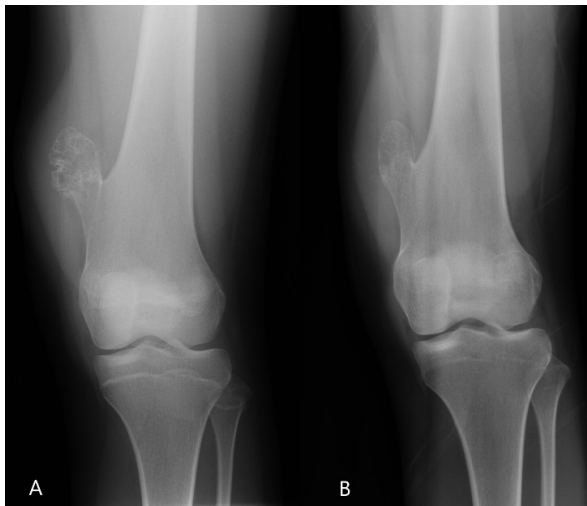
AP view of left knee plain radiograph on (A) initial visit and (B) after six years, showing the 30% reduction in the size of the osteochondroma.
